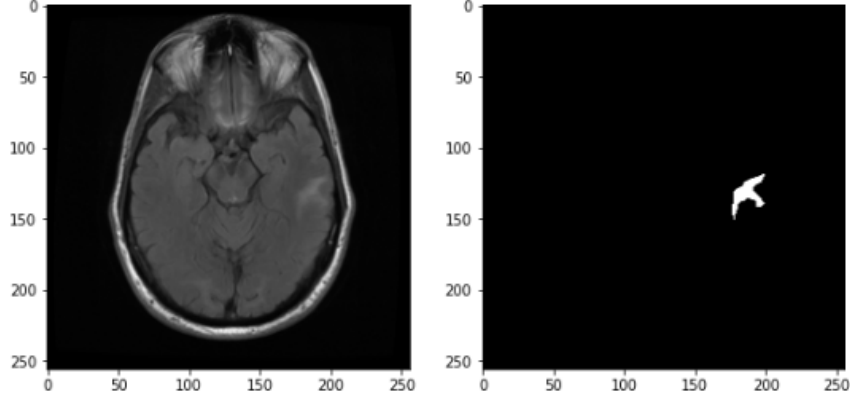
Gray scale MRI with lesion mask
